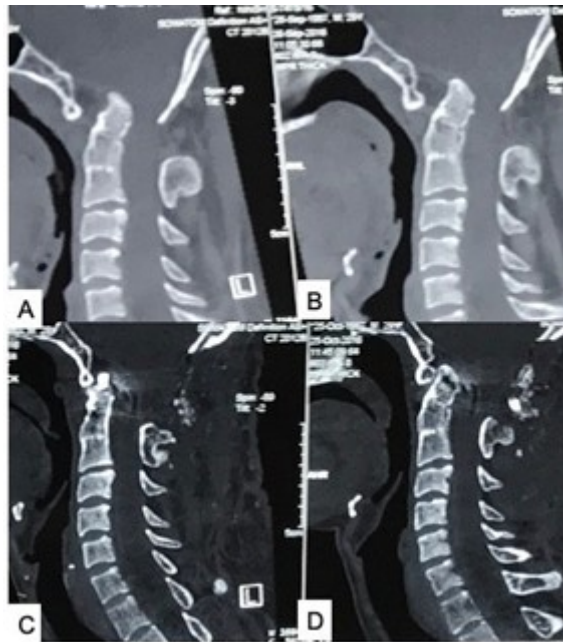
CT scan of CVJ (sagittal images). (A,B) Preoperative images showing AAD with basilar invagination (BI). (C,D) Postoperative images showing vertical and horizontal reduction, stabilization, and fusion. Source: Figure by authors.
